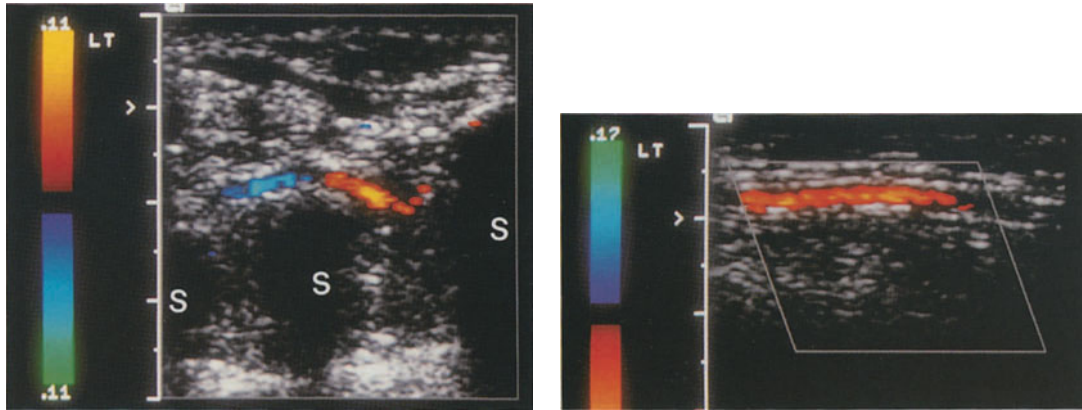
(left) Deep palmar arch (transverse section at the level of the metacarpals): CCDS allows easy identification of the vascular structures (in contrast to the difficulty of vessel demonstration by gray scale ultrasound in this anatomic location). S = shadowing by metacarpal bones
